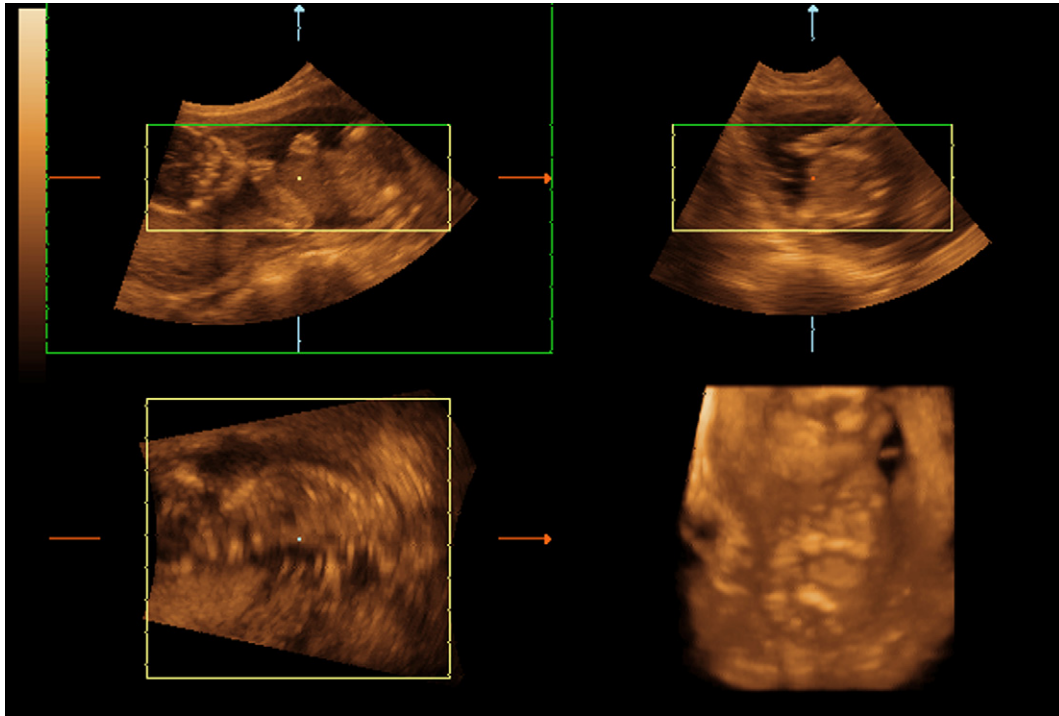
Multiplanar three-dimensional ultrasound (3D US) image of fetal osteogenesis imperfecta at 20 weeks' gestation. The image shows significantly short extremities with bone fracture graphically observed by 3D US.
